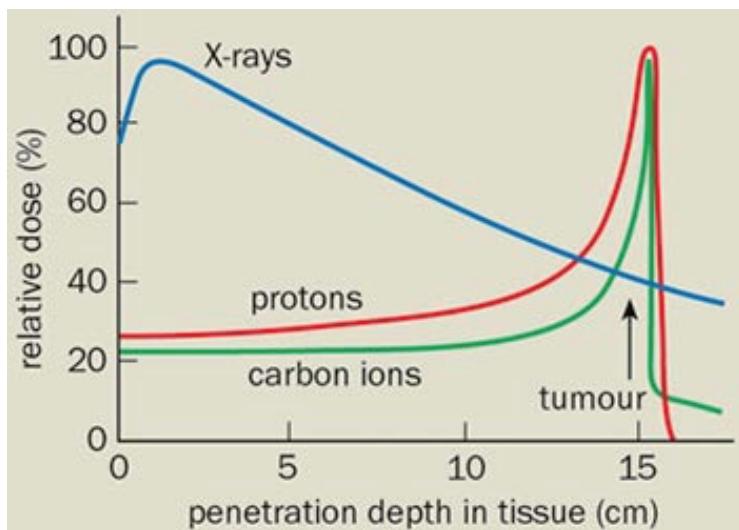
Rationale of using charged particles for cancer therapy. While X-rays deposit more energy on the surface than in the tumor, the opposite holds for charged particles, such as protons and carbon ions.
